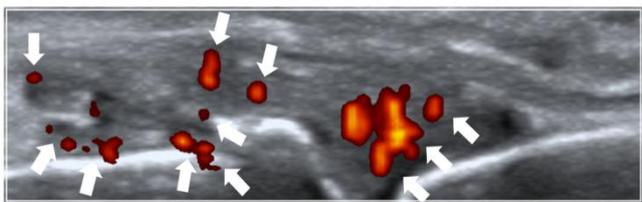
Power Doppler image indicating active synovitis in medial recess
